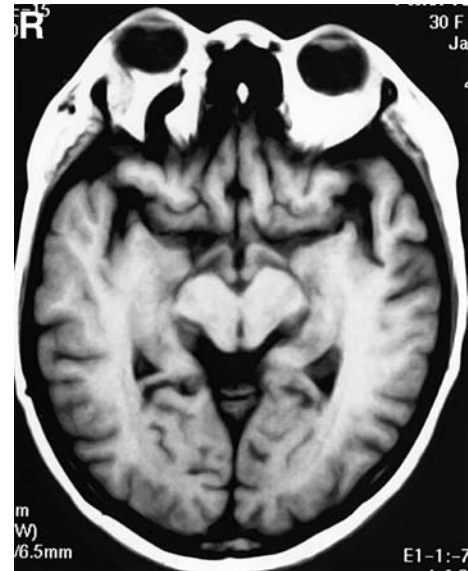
T₁-weighted magnetic resonance image showing a high-velocity signal void in the superior ophthalmic vein, and the proptotic right globe.
